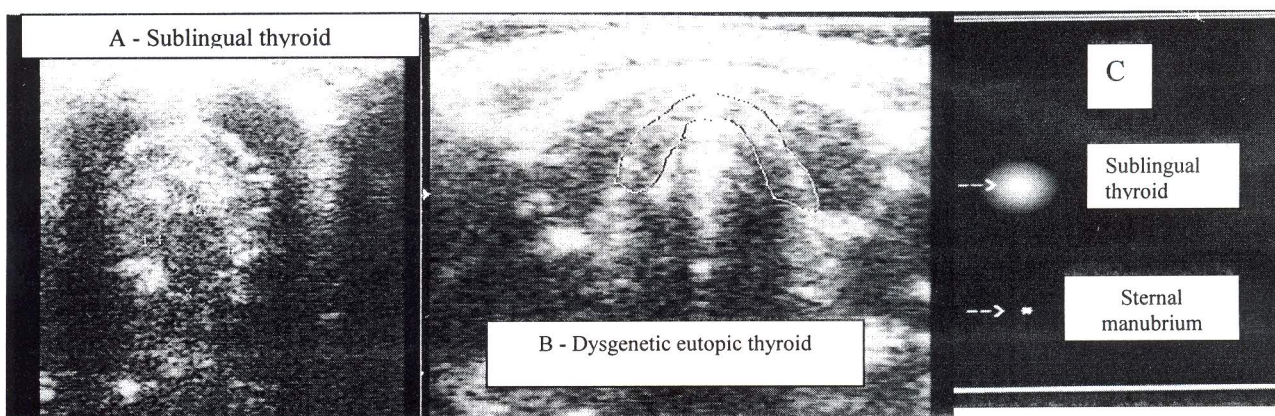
Ultrasound (A and B) and scintigraphy (C) of one patient with an ectopic and dysgenetic eutopic thyroid
